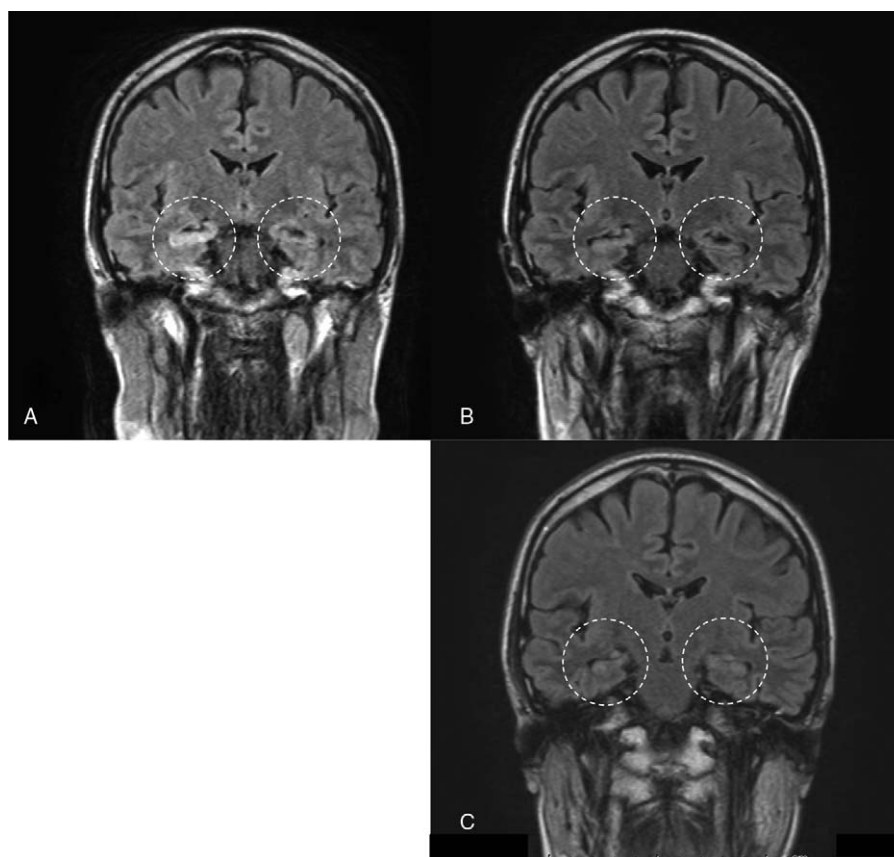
FLAIR MRI images of the patient's brain before and after treatment. (A) The image shows intense signals in the patient's bilateral medial temporal lobes and his hippocampus (dotted circular line). (B, C) FLAIR MRI images showing that the intensities in the patient's bilateral hippocampal lobes became less detectable after treatment for the ONB (dotted circular line).
